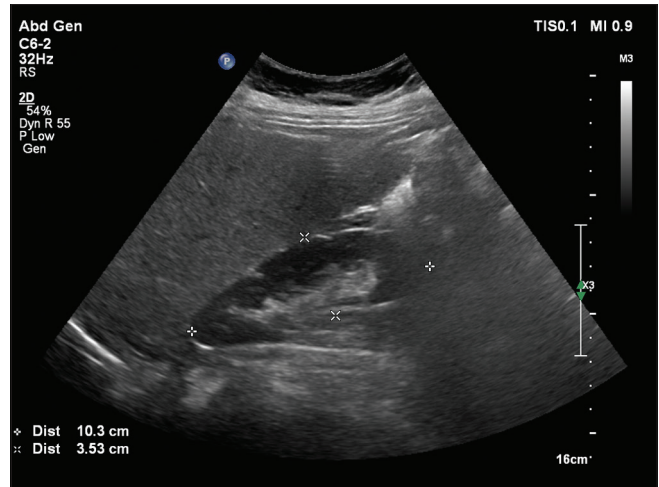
Ultrasound showing oval hyper echoic with central anechoic region
